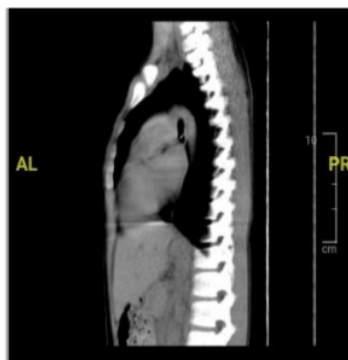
Chest CT Scan with contrast in lateral view
